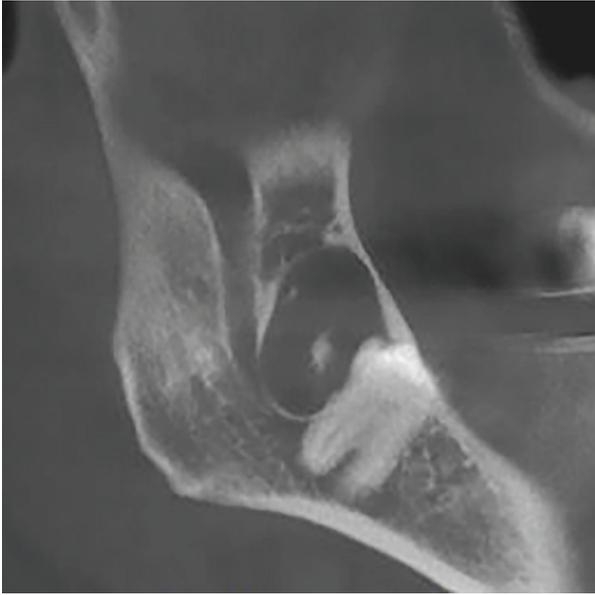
Sagittal CBCT image showing an oval-shaped, lateral-type dentigerous cyst. Note the radiopaque foci inside the radiolucent lesion
